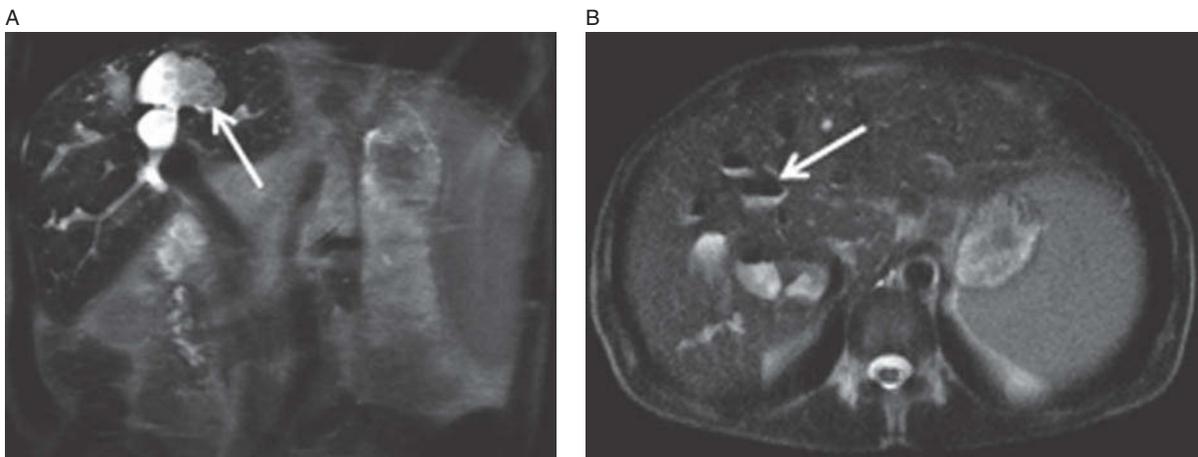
Caroli's disease. Coronal T2-weighted image (A) shows saccular, cystic dilatation of the intrahepatic biliary tree with multiple filling defects (arrow). Are these stones? Axial T2-weighted image (B) demonstrates that these filling defects float and therefore represent air (arrow). Patient has already undergone hepaticojejunostomy.
